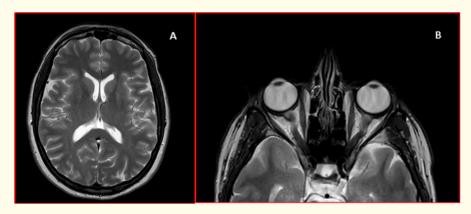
T2-weight axial MRI, showing normal cerebral ventricles (A) and tortuous optic nerves (B).
